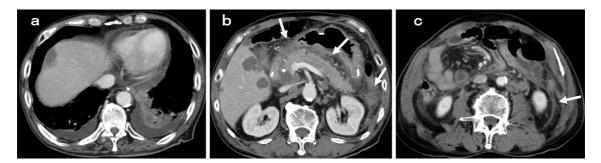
Contrast-enhanced computed tomography two days after the second ERCP procedure showing continuing severe acute pancreatitis findings. a: Bilateral pleural effusion and atelectasis in the left lung. b: Peripancreatic inflammation and inflammation to the abdominal cavity (arrows). c: Inflammation spread around the left kidney (arrow). ERCP: endoscopic retrograde cholangiopancreatography
